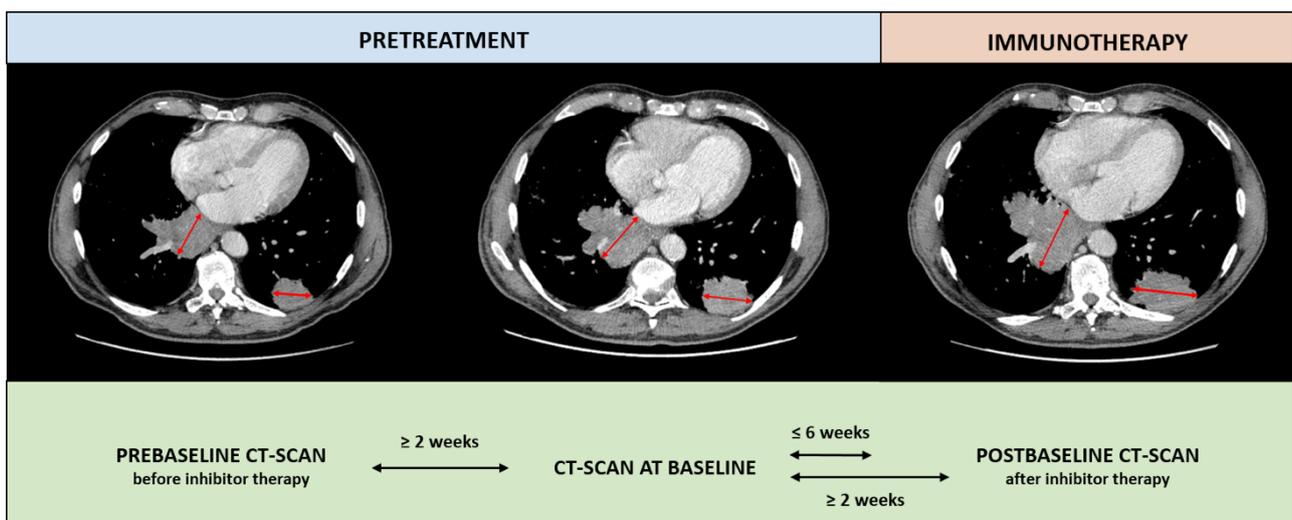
Case study of a patient with hyperprogressive disease. At least 3 CT-scans were required to assess the dynamic indices allowing us to define HPD since variations of size and volume were calculated both before and during the PD-1/PD-L1 therapy. The baseline CT-scan needed to be performed within 6 weeks before the initiation of the immunotherapy.
